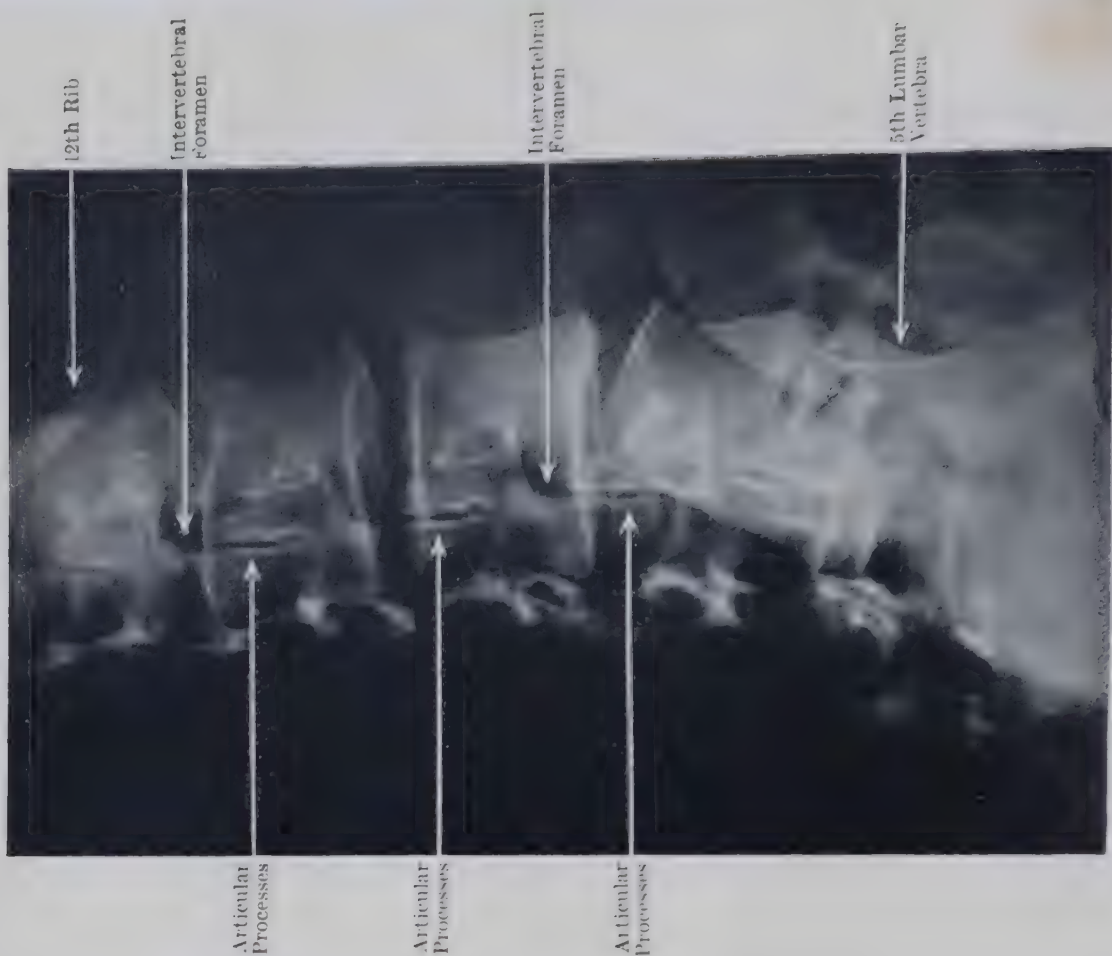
OBLIQUE LATERAL RADIOGRAPH OF LUMBAR VERTEBRÆ OF WOMAN AGED 59 TO SHOW THE JOINTS BETWEEN ARTICULAR PROCESSES.
